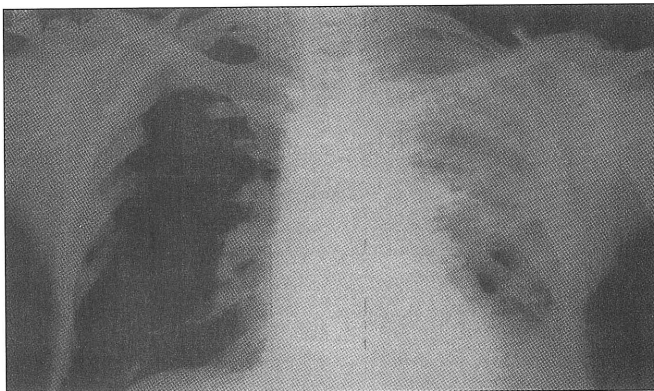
Chest CT of patient: Interstitial type pneumonic consolidation on the left lower lobe
